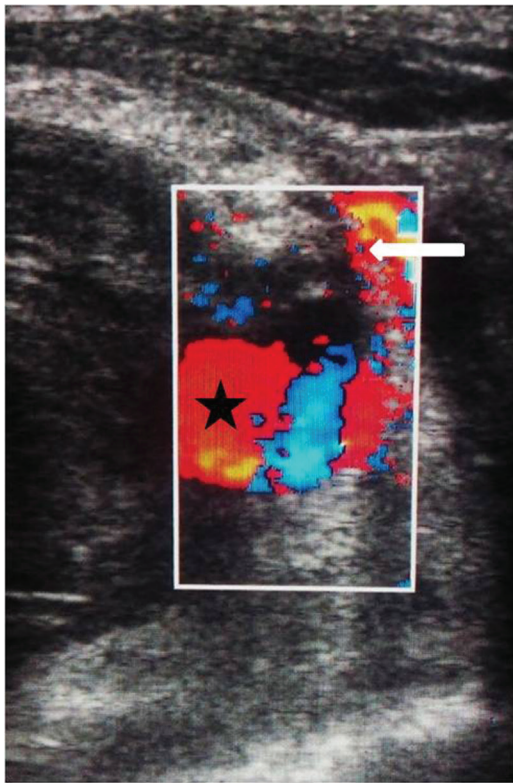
Color Doppler image showing turbulent flow within the pseudoaneurysm (asterisk) with a narrow neck, with flow seen in the inferior thyroid artery (white arrow).
